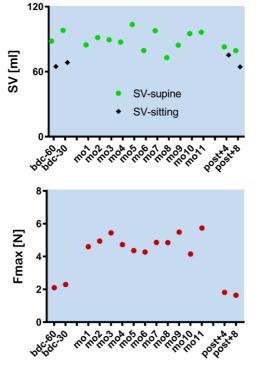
Stroke volume (SV) estimated from transthoracic impedance cardiography (top) and maximum ballistic cardiac force (Fmax, bottom) during 12 month space flight.
